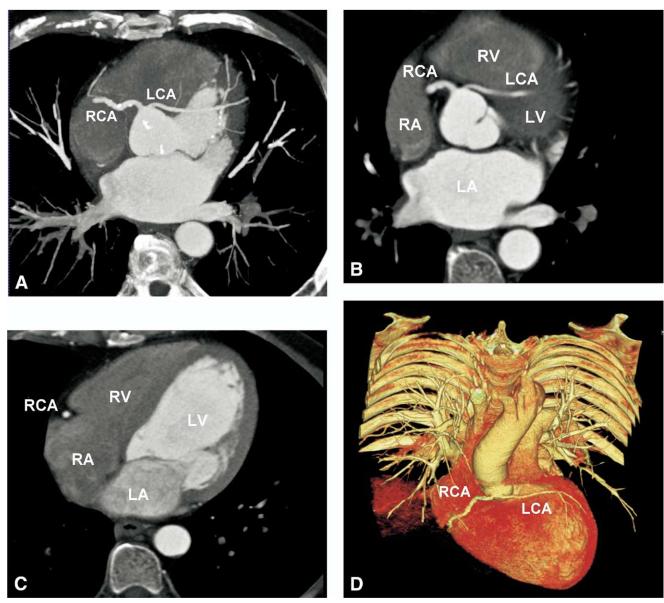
Contrast-enhanced CT coronary angiography with saline chasing technique in a patient with anomalous origin of the left coronary artery from a common ostium with the right coronary artery. Use of a saline chaser bolus results in contrast enhancement almost exclusively of the arterial side of the cardiac circulation (left ventricle, LV; left atrium, LA) with high and consistent opacification and exquisite delineation of the right coronary artery (RCA) from the significantly less enhanced right ventricle (RV) and right atrium (RA). This facilitates threshold-dependent 3D visualization (D) of this vascular anomaly, since a single, predetermined threshold enables uniform rendering of the entire coronary artery tree. (Color version of figure is available online.)
